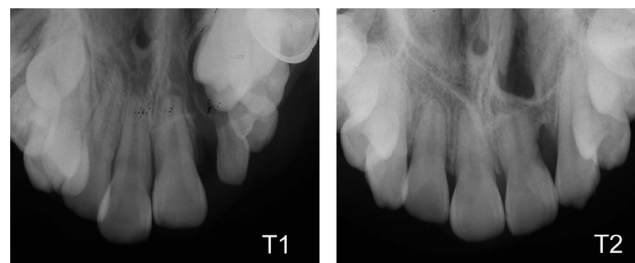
Occlusal radiographs showing central incisors before secondary alveolar bone grafting (T1) and after edgewise treatment (T2) in a patient with unilateral cleft lip and palate on the left side.
